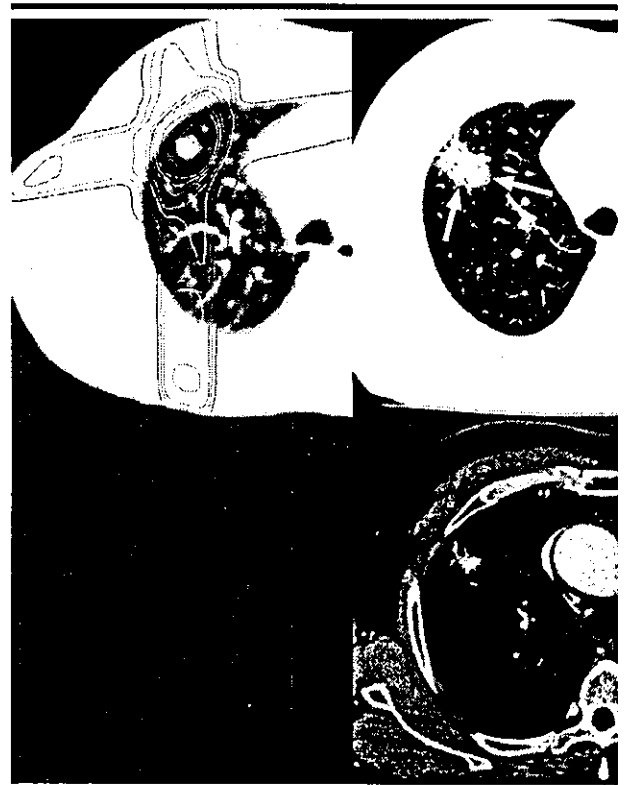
Transverse CT images show a representative case of round-shaped radiation-induced pulmonary injury. Left: Image obtained for treatment planning at the isocenter. Right and bottom: Images obtained 4 months after SRT. Round-shaped patchy consolidation was observed around the tumor (arrows).
